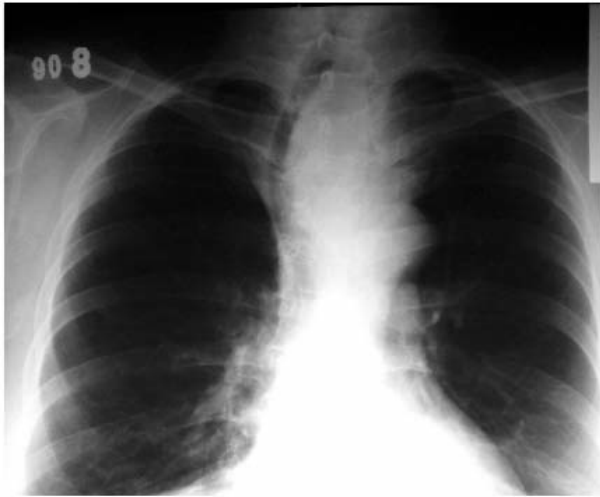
Posteroanterior chest radiography in a patient with tracheal deviation.
